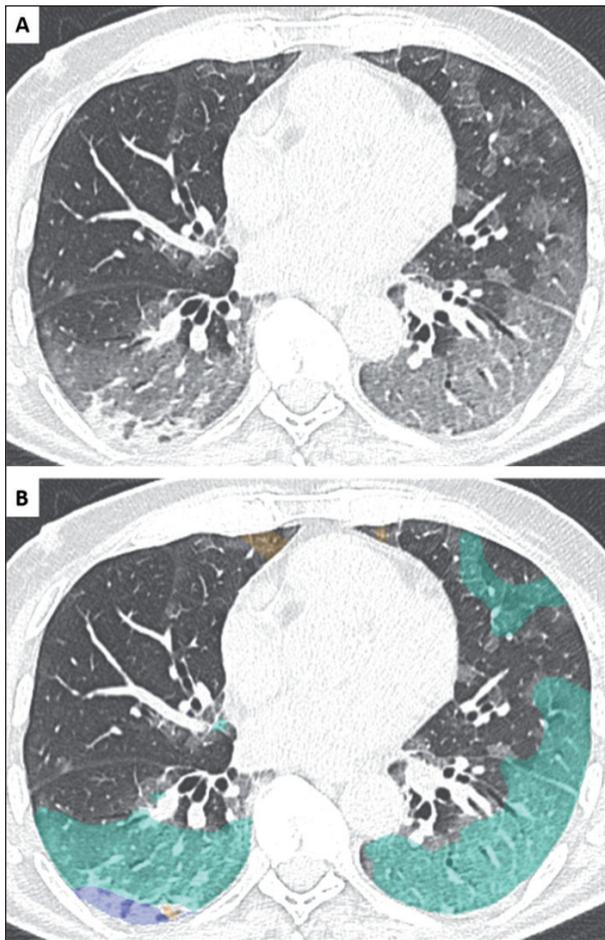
High-resolution computed tomography (HRCT) in a 50-year-old man with COVID-19 pneumonia. (A) Axial HRCT image depicts bilateral, extensive ground-glass opacities admixed with consolidations. (B) The corresponding color-overlay image derived from a texture-based automated quantification system shows extents of different regional patterns: green= ground-glass, violet= consolidation, yellow= reticular opacity.
